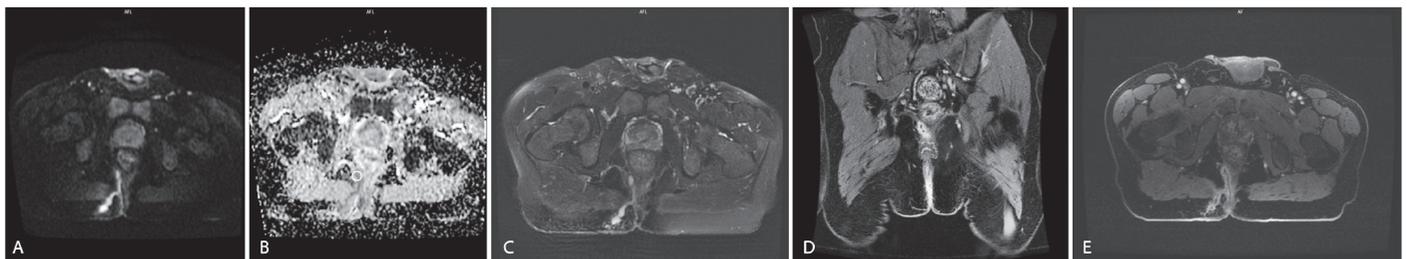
A) DWI of a grade 1 perianal fistula with increased signal along the fistula tract. B) ADC image of DWI showing decreased signal intensity within the fistula lumen, consistent with diffusion restriction and thus inflammatory pus. The circle denotes the position of the ROI, which measured a mean ADC of 0.910x10⁻³ mm²/s. The fistula was classified active. C) Fat-suppressed T2W of the same fistula with high signal of the fistula lumen against a background of low signal. D, E) Post-contrast coronal and axial T1W images showing intense mural contrast enhancement of the fistula tract
